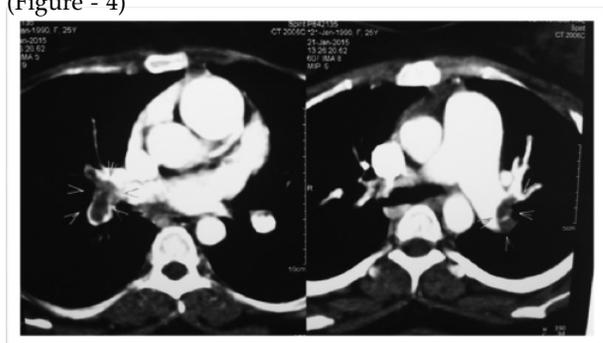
CT Pulmonary Angiography showing massive thrombus in right and left main pulmonary artery
